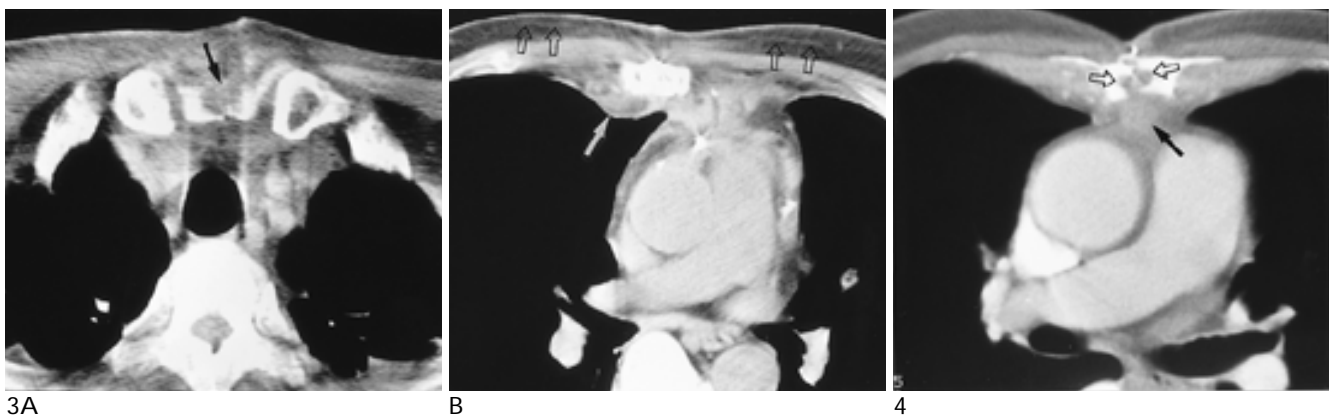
64-year-old man with osteomyelitis of the sternum. The patient had had CABG 40 days before, and was suffering from fever, discharge, and substernal pain. No drainage procedure was performed between the initial operation and the CT exam.
